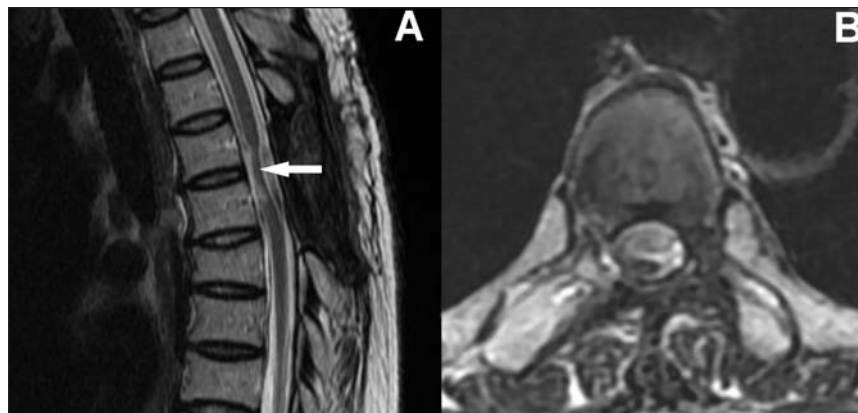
A, B. Three month postoperative midsagittal and axial T2-weighted magnetic resonance image demonstrating the return of the spinal cord to a more normal position. Persistent atrophy of the spinal cord with focal myelomalacia is present (arrow).
